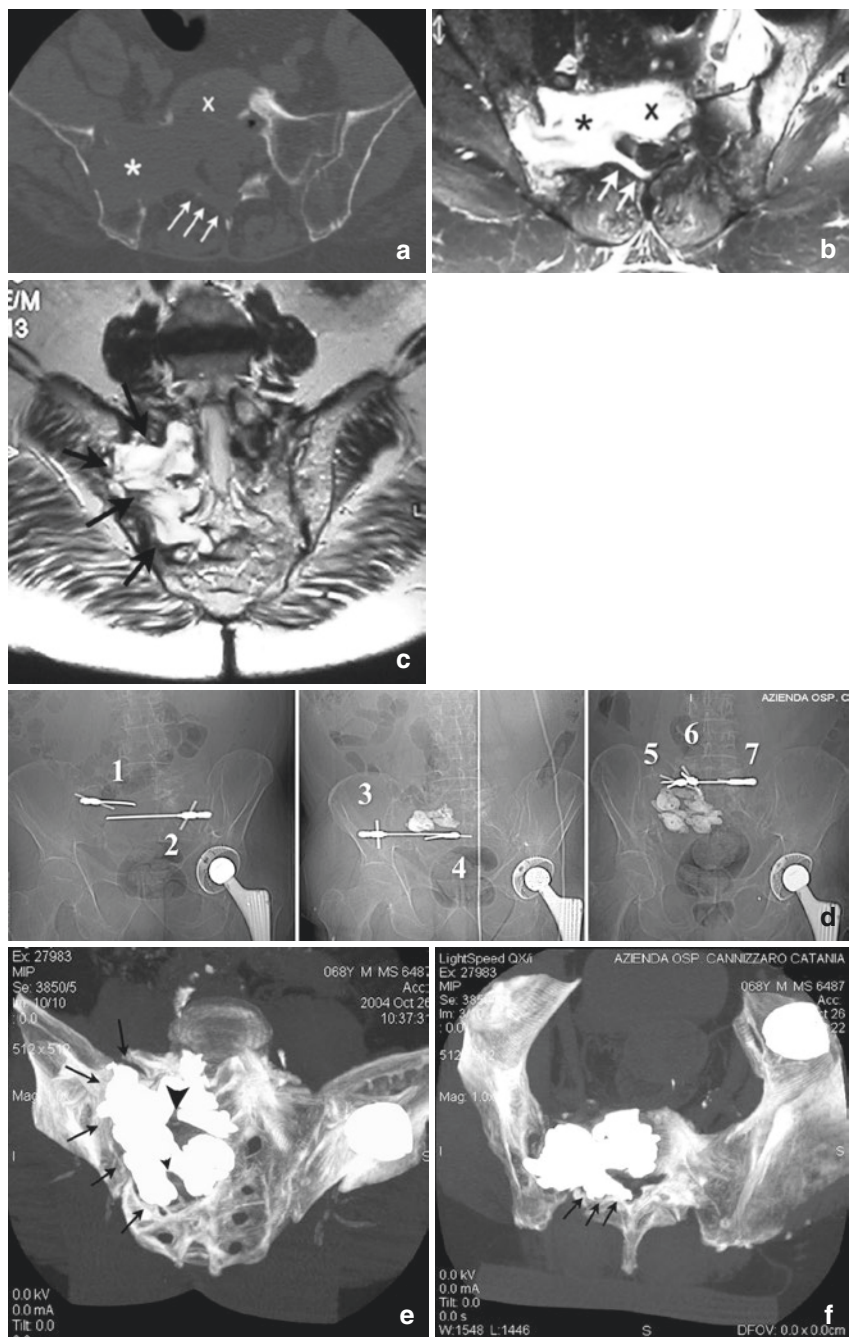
Severe sacrum osteolysis related to multiple myeloma disease in a 58-year-old male. On axial CT (a), MR (b), and coronal (c) scans, full involvement of the right sacral wing, iliac bone, S1–S3 sacral body, as well as the posterior right wall of the sacral canal can be appreciated. A three-stage treatment was planned, using seven needles. After PMMA injection, full reconstruction of the sacrum and right iliac bone and recreation of the I and II right sacral foramina (e) and sacral canal (f) can be appreciated
